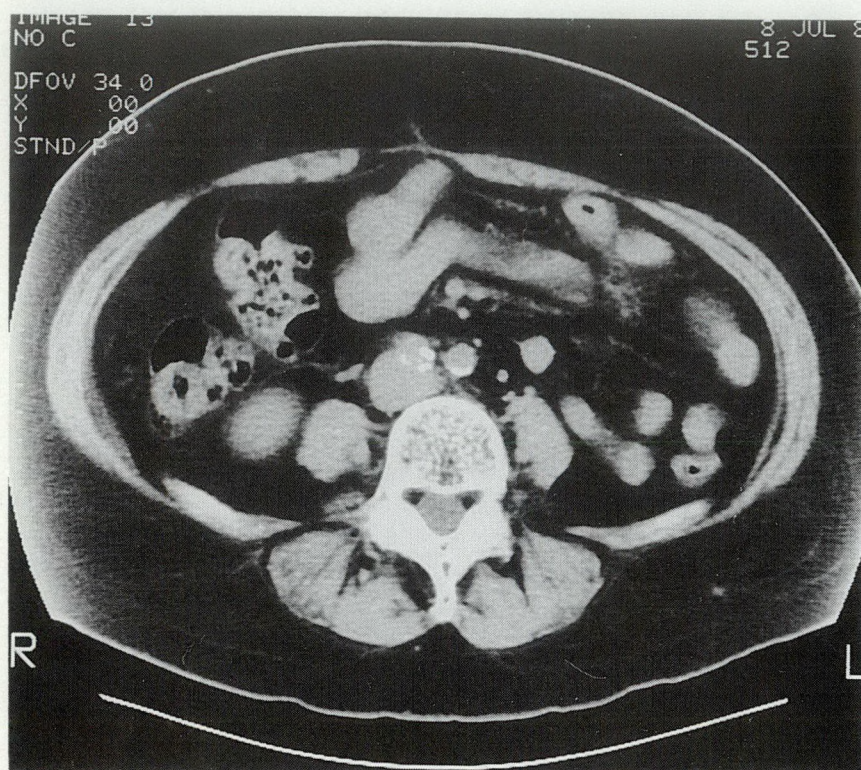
Computed tomography scan of common iliac arteries at follow-up.
